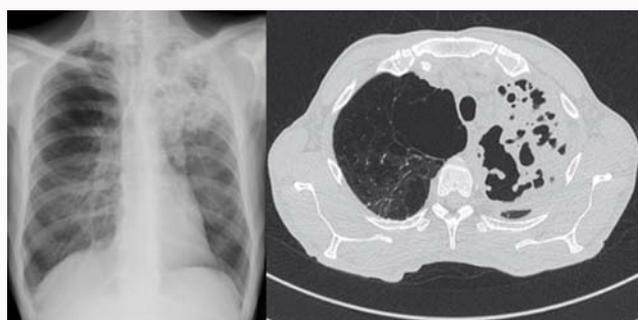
A month later - Case 1. Worsening is evident. On the X-ray, the appearance of a coarse opacity with poorly defined margins is observed, due to the presence of cavitative phenomena which are confirmed by CT examination.
